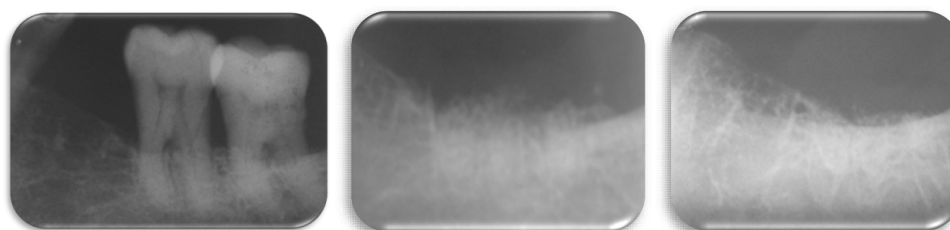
Radiography evaluation: initial, after 7 days and after six months of treatment.
